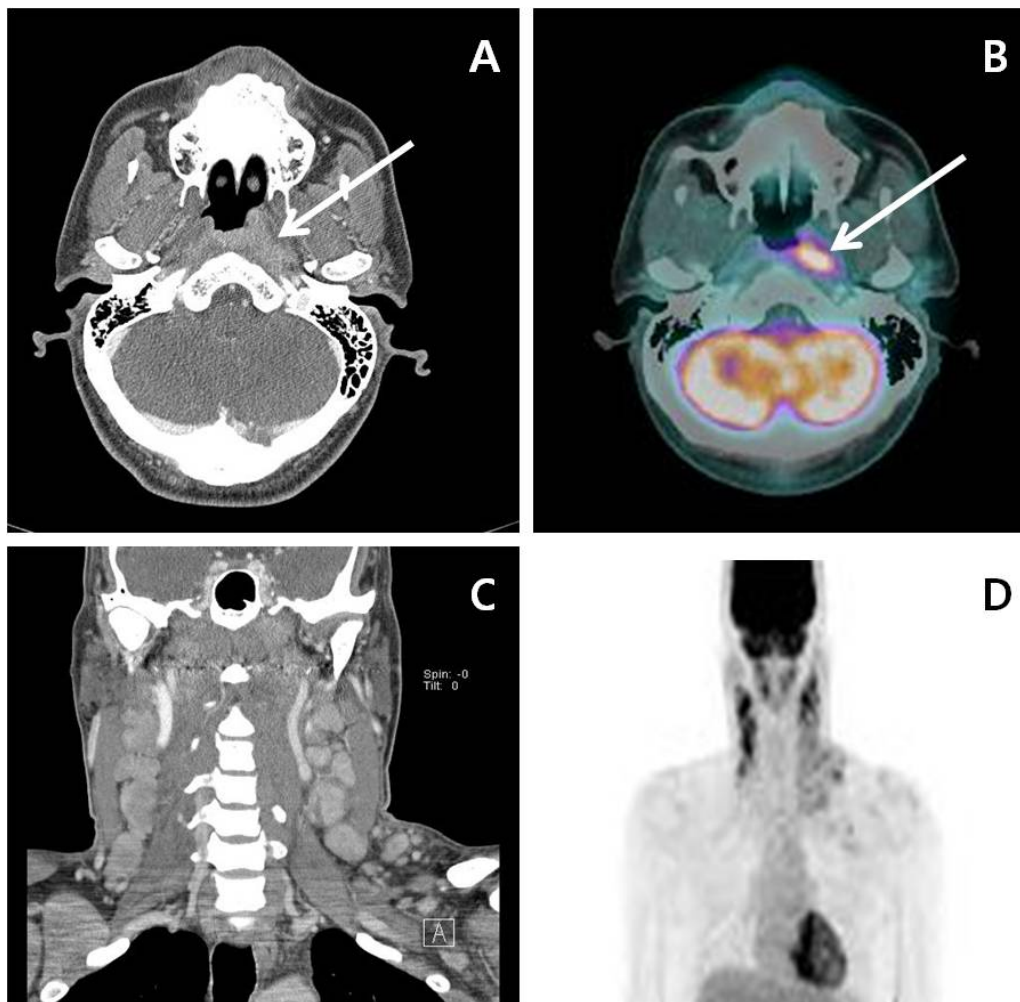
Neck computed tomography and Positron emission tomography-computed tomography (PET-CT) before treatment. A-B: Left nasopharyngeal mass infiltration to the parapharyngeal space (standardized uptake value [SUV] max of 7.36); C-D: Both lymph nodes at level II, III, IV, V, and the left supraclavicular area. The largest was measured at 3 cm in diameter .
